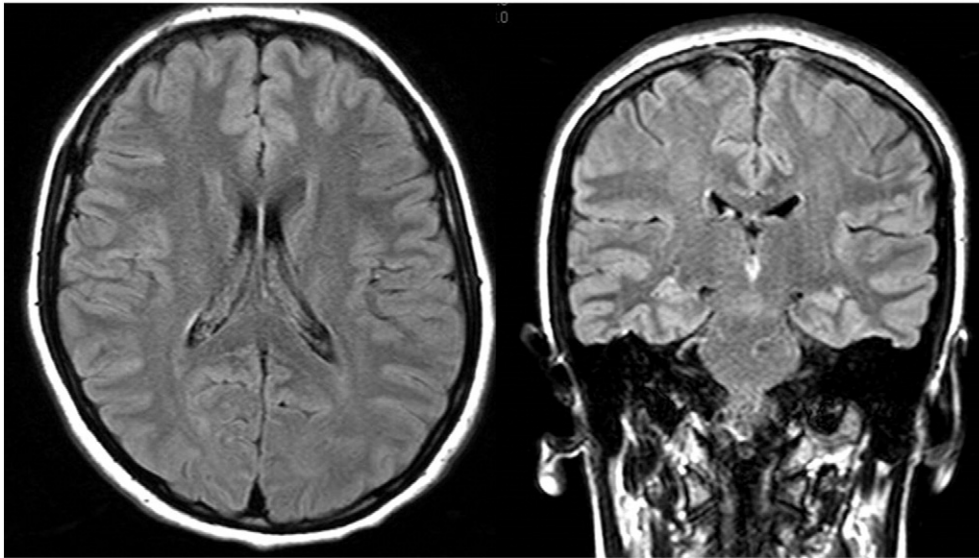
Cranial MRI was unremarkable.
